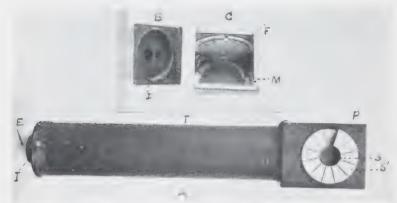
A modified form of the Benoist penetrometer, the most reliable of all the instruments devised for the direct determination of the approximate degree of penetration of the major portion of the x-ray output. While by no means exact, and not adapted for routine use nor suitable for general dosage estimation, this instrument possesses a distinct value in testing the output of tubes in order to determine its quality in a general way, especially when the quality of the output is uncertain. A, shows the instrument intact, consisting of a telescopic tube, T, with an aperture for the observer's eye at one end, E, and a diaphragm, D, at the other end, B, which can be seen on removing the wedgeshaped box, P, the interior of which is shown in C. Into the front of this box, P, which is to be held directly facing the target of the excited x-ray tube, is inserted a standard silver disk, S, surrounded by twelve aluminum sectors, S', which increase regularly in thickness from the first to the twelfth, so that the latter is twelve times the thickness of the first. Behind the silver disk and sectors is placed a fluoroscopic screen, F, which is illuminated by the rays from the excited tube which pass through these metals. On the inner surface of the screen are mounted lead numerals corresponding to the numbers of the respective aluminum sectors. On looking through the instrument, the observer sees the reflection of the illuminated screen in the mirror, M, placed at 45° , but the two apertures in the diaphragm, D, permit only the reflected portion corresponding to the silver disk, S, and one of the aluminum sectors, S', to be seen at one time. When using the instrument, the operator revolves the diaphragm, D, by means of the indicator, I, until the degree of reflected illumination back of one of the aluminum sectors matches that back of the central standard silver disk. The number of this sector is indicated either by its lead numeral on the screen, F, or on the circular scale around which the indicator, I, revolves. This number indicates in terms of the Benoist scale the approximate degree of penetration of the major portion of the rays generated at the time, but the proportion of the output which is thus represented is a very indefinite and variable quantity, however.
